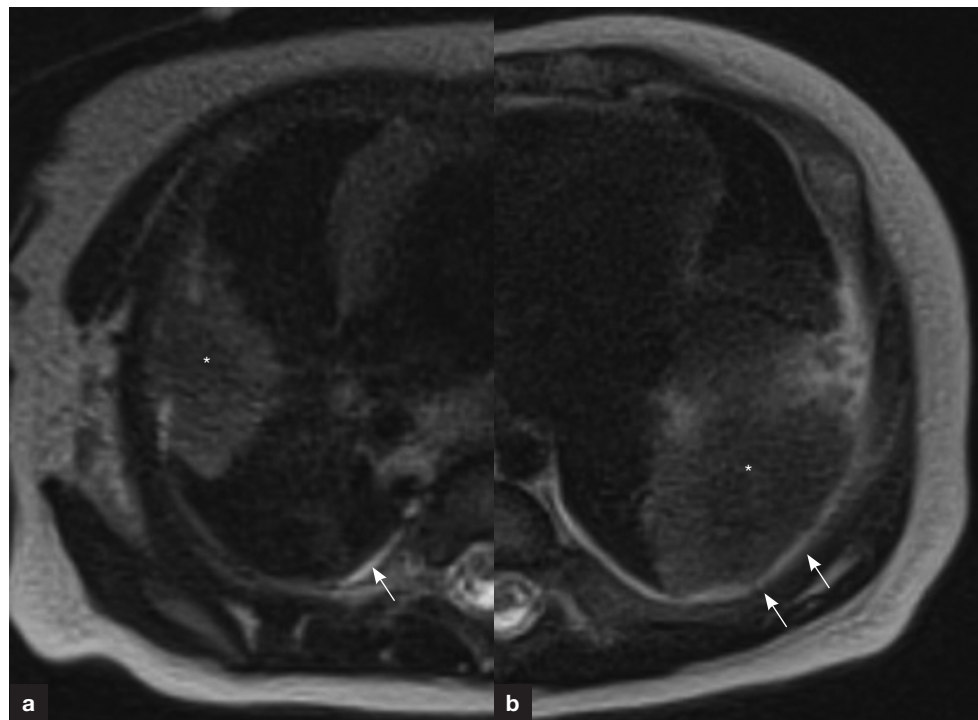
T2-weighted magnetic resonance images revealing peripherally located lung consolidations (asterisk) of (a) right upper and (b) left lower lobes. Pleural involvement is also apparent on both hemithoraces (arrows).
